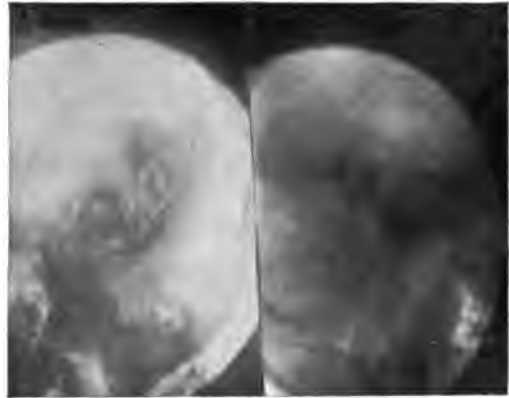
CASE 6343. FEMALE AGE 22. SAME TYPE AS ROENTGENOGRAM FIG. 10.
